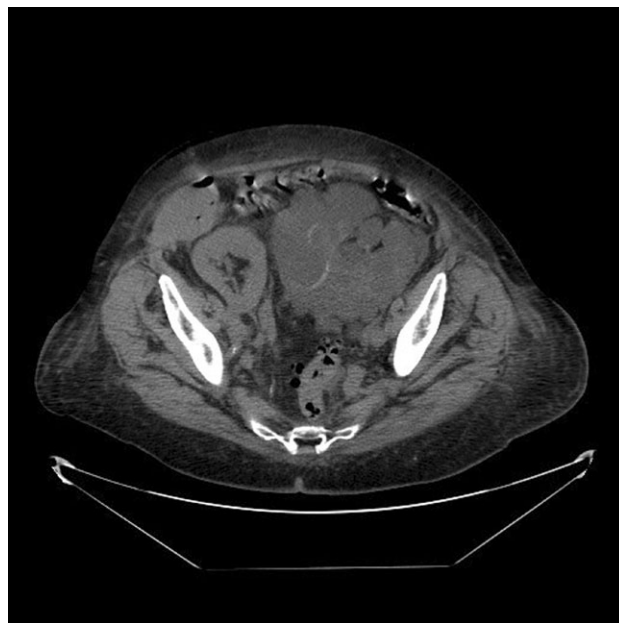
Computed tomography showing a renal transplant lying in the right iliac fossa and a polycystic left native kidney arising from within the patient's pelvis.
